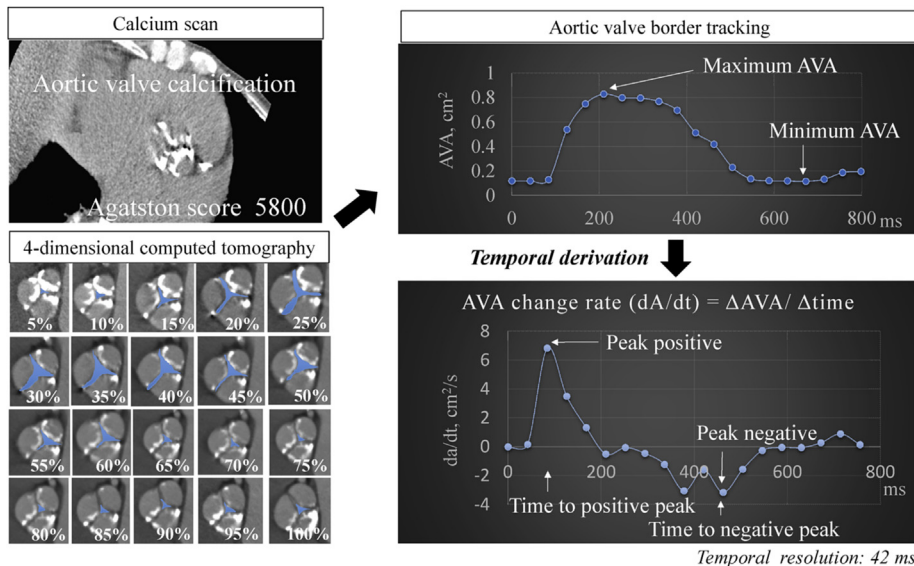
Quantitative assessment of aortic valve area tracking using dynamic multidetector computed tomographic imaging. Maximum and minimum aortic valve areas, peak da/dt, and time to peak da/dt were determined from the curves. da/dt represents the rate of change of aortic valve area during opening (positive) or closing (negative).
